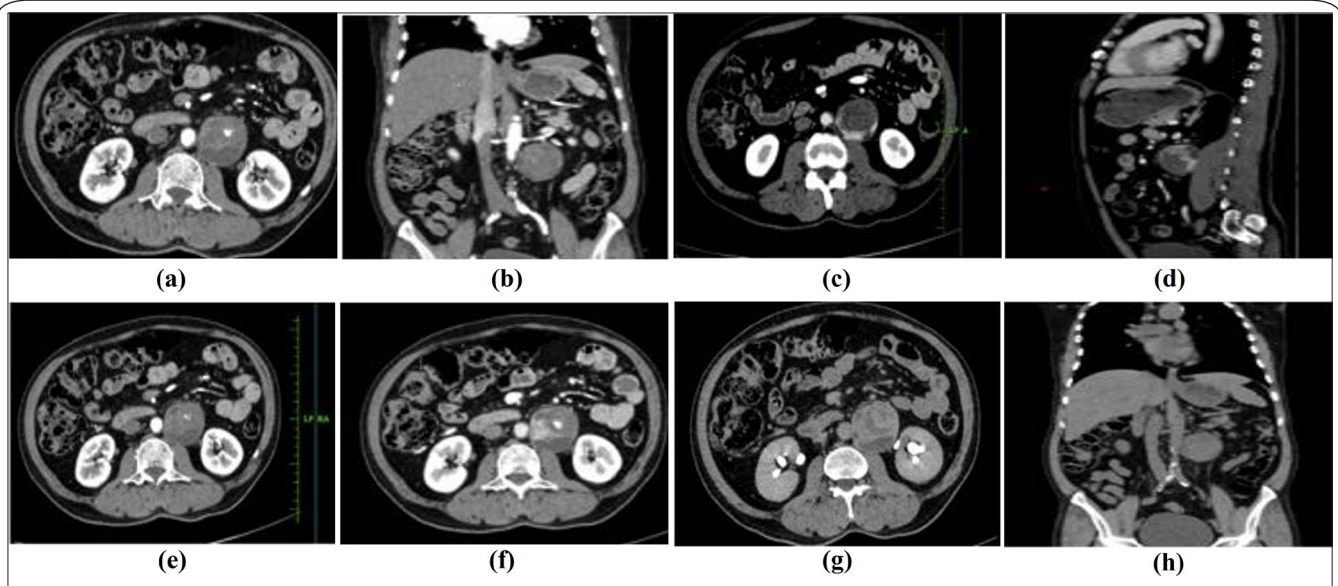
CT abdominal angiography arterial phase (a) axial and (b) coronal, (c, e, f) venous phase axial and (d) sagittal, and delayed phase (g) axial and (h) coronal images suggestive of highly vascular retroperitoneal mass lesion, which is showing no obvious communication or leak from the abdominal aorta communicating with the para-aortic mass lesion.
